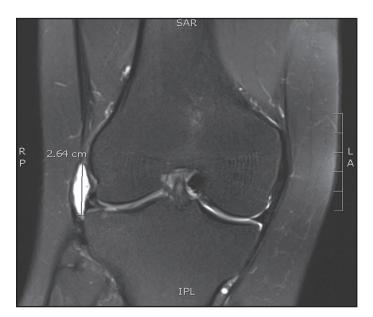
A coronal slice T2-weighted MR image shows a very large anterolateral parameniscal cyst, demonstrated by the discrete, well-defined hyperintense signal adjacent to the meniscus, in addition to a horizontal-oblique lateral meniscus tear, demonstrated by the linear hyperintense signal within the lateral meniscus that extends to the articular surface.
